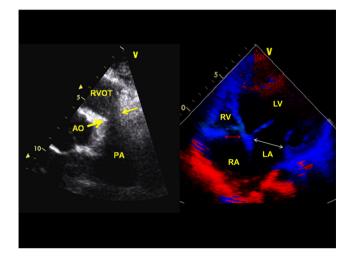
Parasternal short-axis view (left panel) showing absent pulmonary valve and hypoplastic pulmonary annulus and the main pulmonary artery. The distal pulmonary arteries are markedly dilated. The right panel shows hypo-plastic tricuspid annulus (14 mm) compared to 29 mm mitral annulus in diastole.
